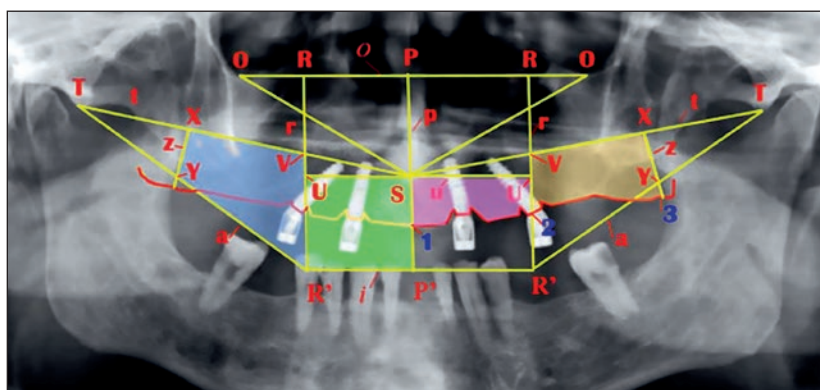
Traced panoramic radiographs with reference lines and points.
